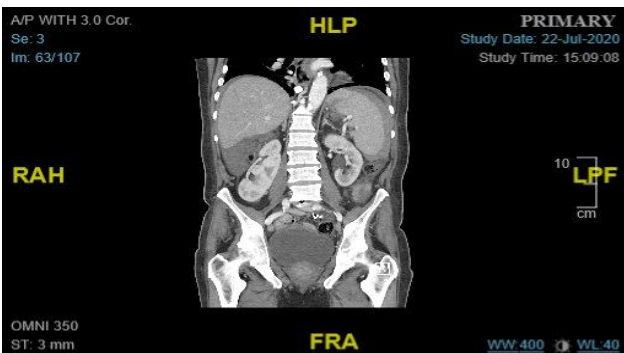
Coronal CT abdomen/pelvis (with PO/IV contrast), shows spleen enlarged to 14 cm in largest dimension with hemoperitoneum around the spleen.
